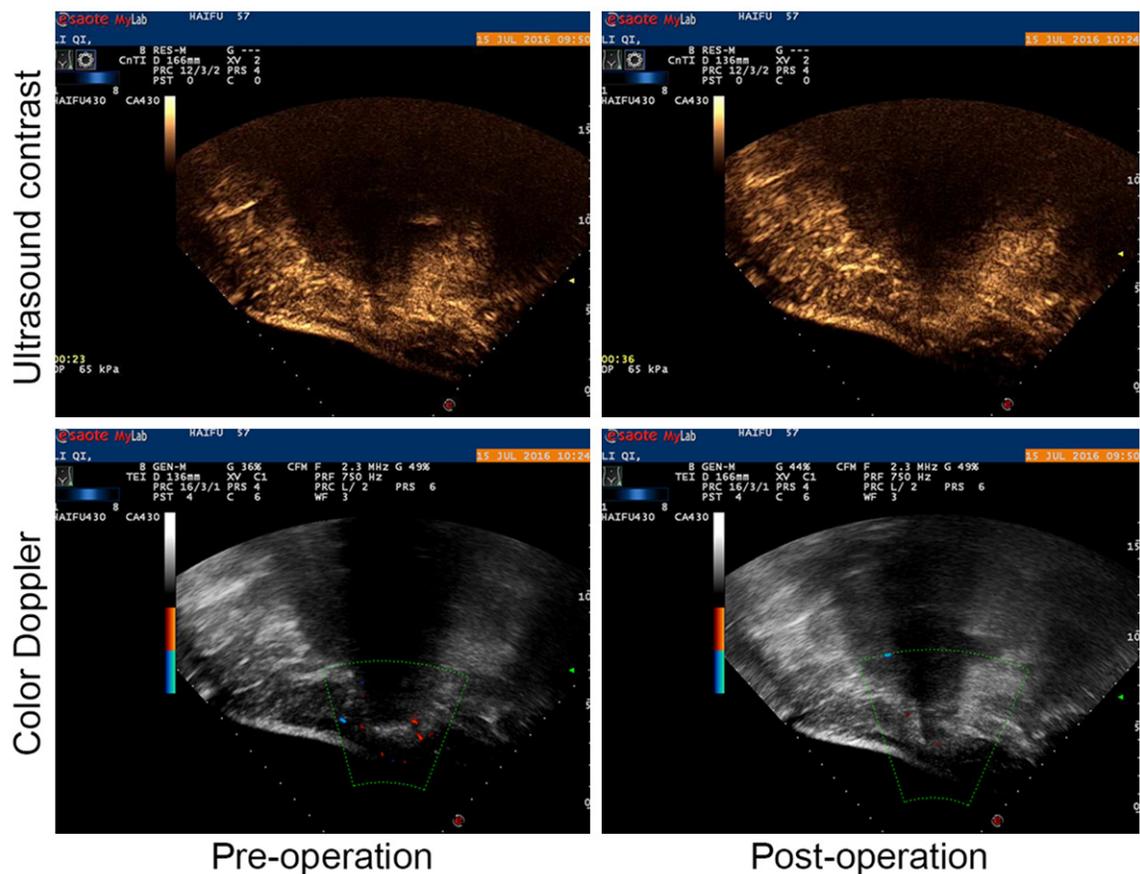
Pre-operation and post-operation ultrasound contrast and color Doppler images of patients with abdominal wall adenomyosis.
